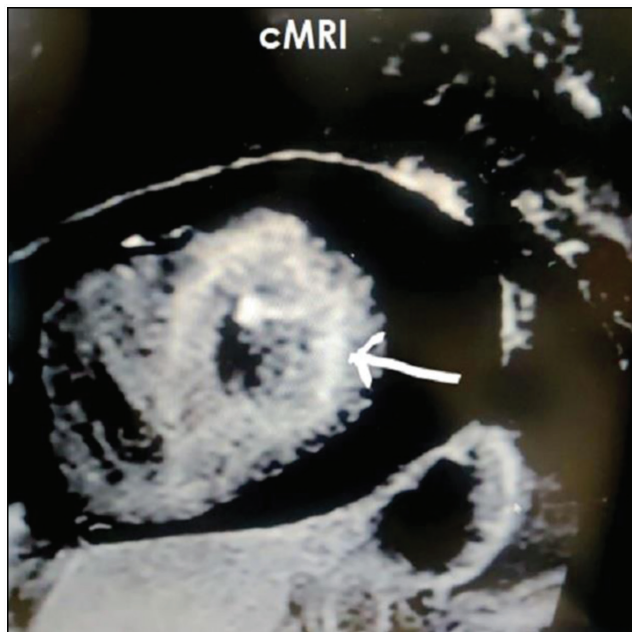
cMRI showing subendocardial LGE of LV, RV, and concentric LVH (single white arrow). Abbreviations: cMRI: cardiac magnetic resonance imaging, LV: left ventricle, RV: right ventricle
